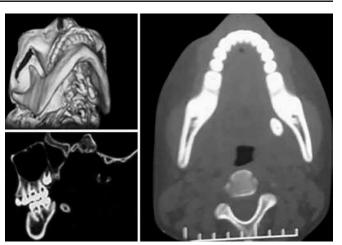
CT scan images (axial, sagittal, 3D) showing a calcified lesion in left submandibular gland
